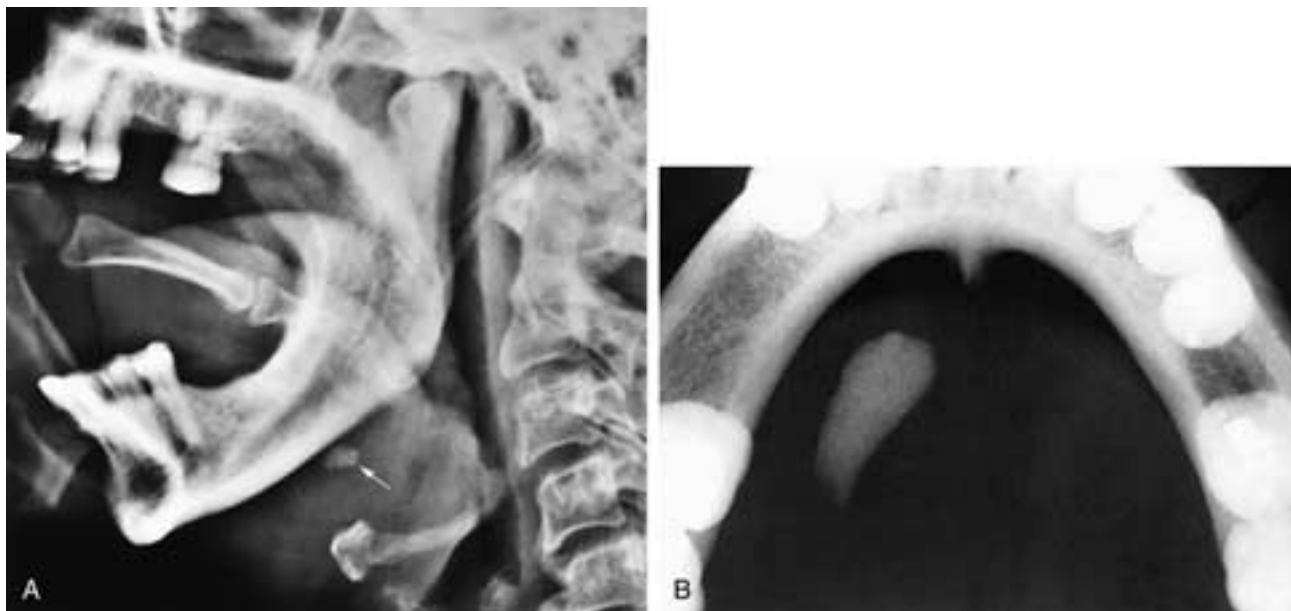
Lateral plain film (A) with the patient's index finger depressing the tongue demonstrates a submandibular gland calculus (arrow) that was hidden by the mandible on a routine lateral film. Intraoral occlusal film (B) shows a large calculus in Wharton's duct. Stones in this location may go unobserved on plain film studies if an intraoral occlusal film is not used.
